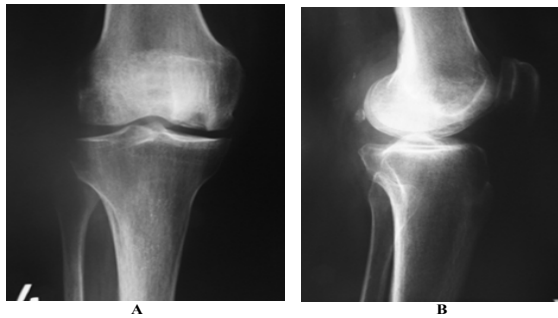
Knee X-ray (A: Antero-Posterior View, B: Lateral View): Osteolytic Lesion of Medial Femoral Condyle.
